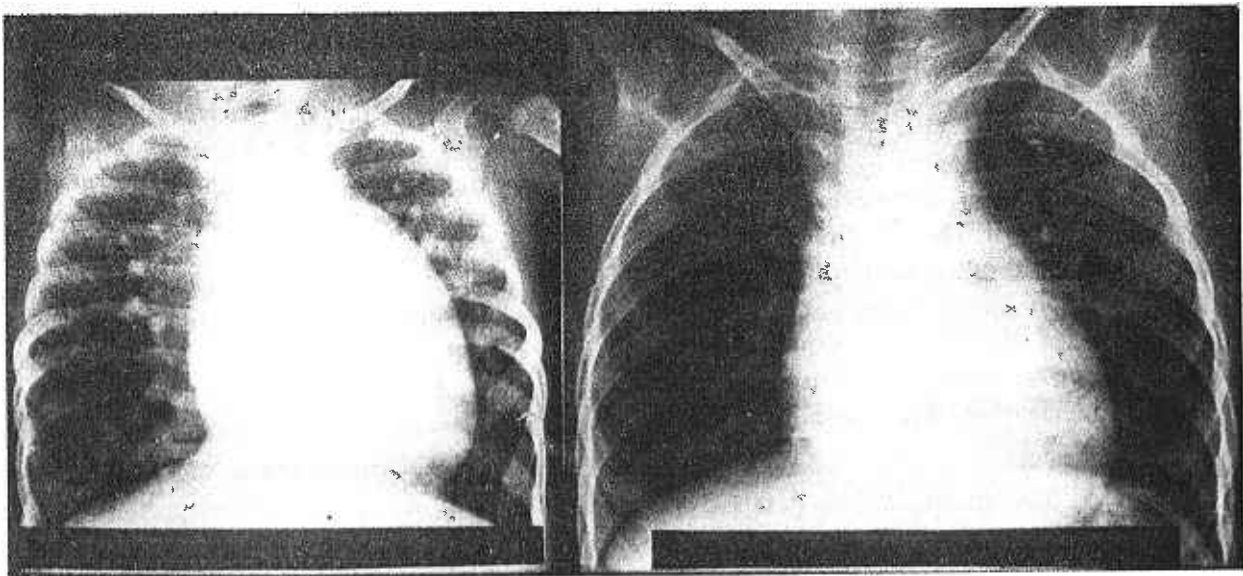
The chest X-ray on the left shows marked pulmonary plethora (L-R shunt of 6.4 L/min.) at the age of 1 1/2 years and that on the right shows oligoemic lung fields at 5 years.
